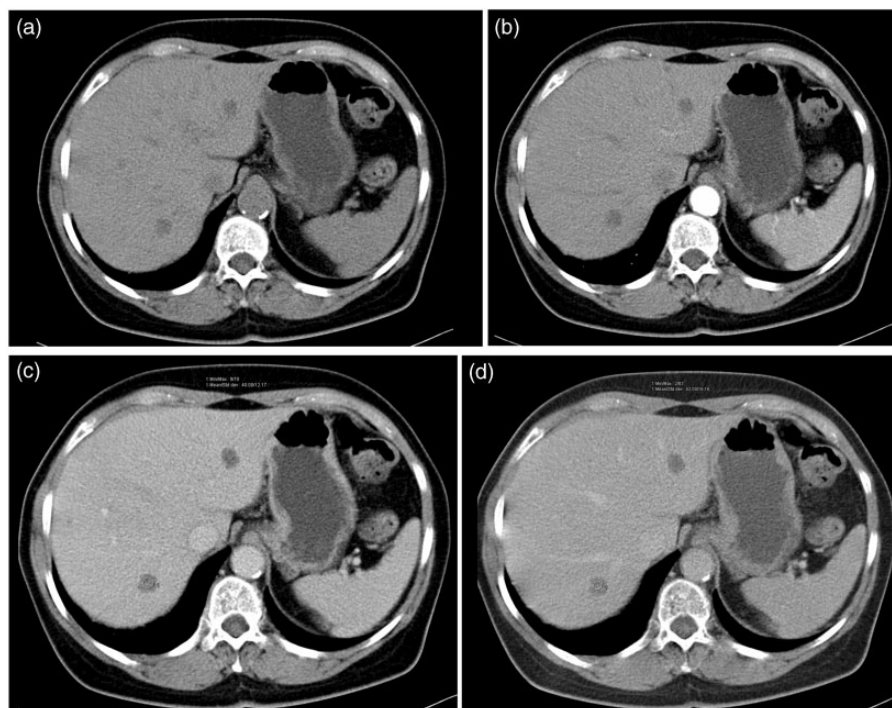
A four phase CT scan through the liver. (a) Pre-contrast axial image showing two irregular low density (40 HU) lesions of 2 cm in segments II and VII. None of the lesions showed contrast enhancement. (b) Arterial phase. (c) Portovenous phase. (d) Late phase (5 min).
